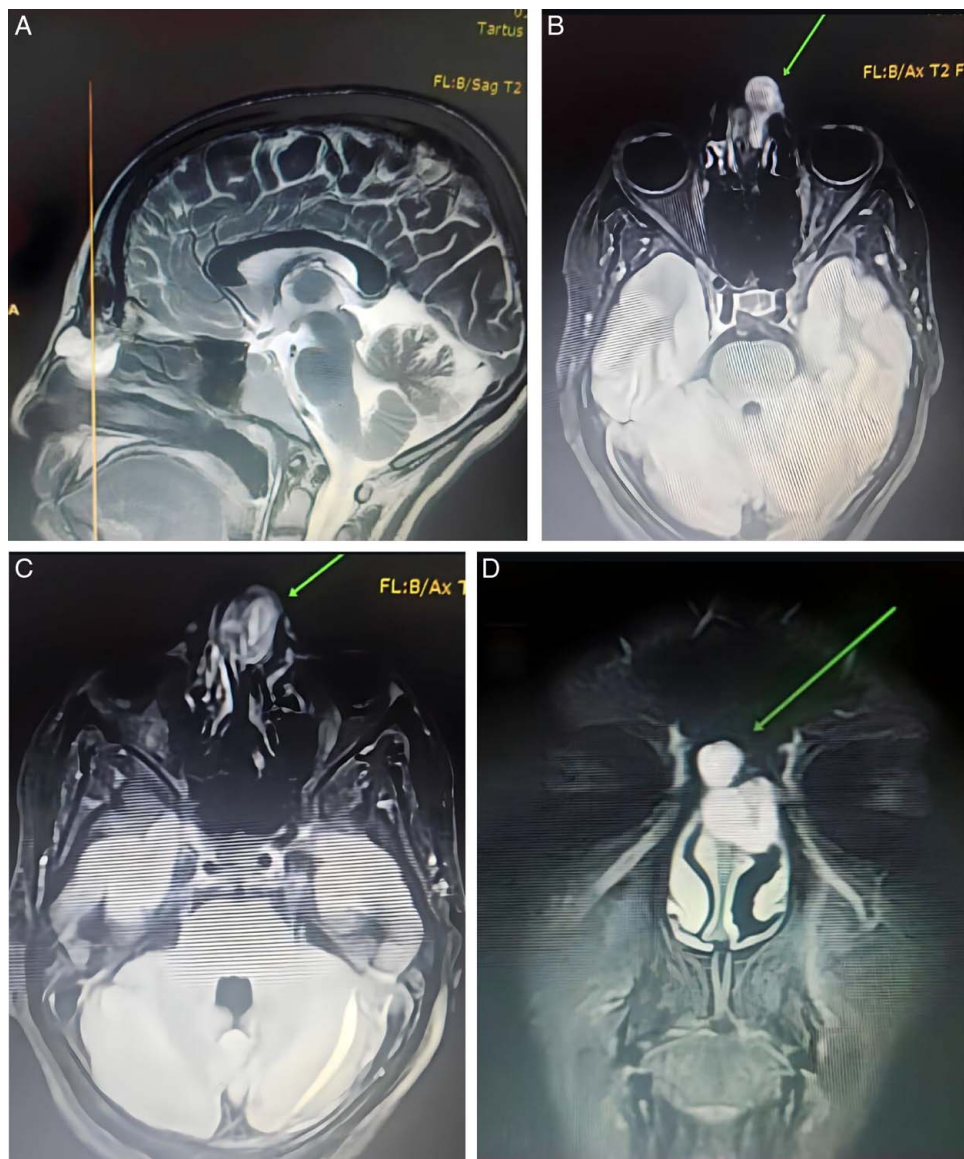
MRI findings. (A) Sagittal MRI shows a heterogeneous cyst at the root of the nose with no evidence of intracranial extension. (B, C) The same findings in an axial MRI were found. (D) The coronal view reveals that the cyst extends to the frontal sinus.
